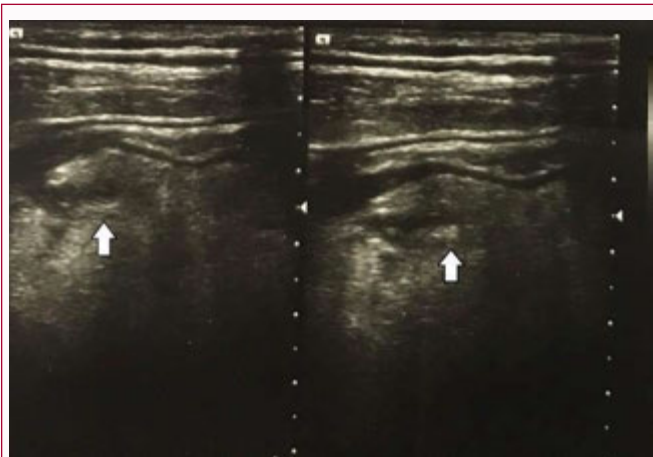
Ultrasound - Hypoechoic tubular structure with collection at RIF and Appendicolith (arrowheads).
